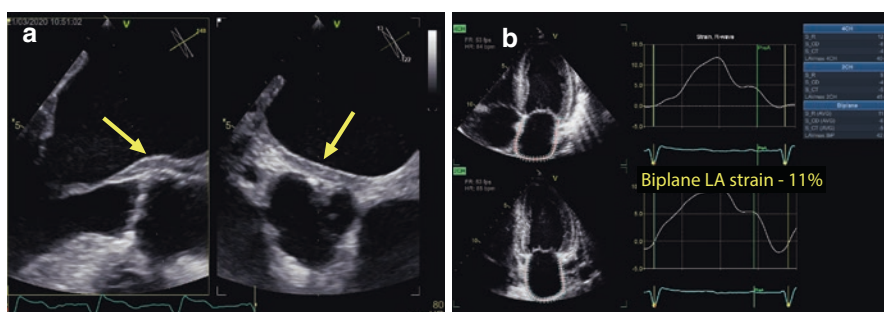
ATTR-wt Amyloidosis patient. Transesophageal echocardiogram (a) showing infiltration of left atrial wall with amyloid (arrow). In (b) from a transthoracic echocardiogram (apical biplane—4 chamber and 2 chamber) we can see markedly reduced bidimensional longitudinal left atrium strain, resulting from diastolic dysfunction and contribution of atrial myopathy
